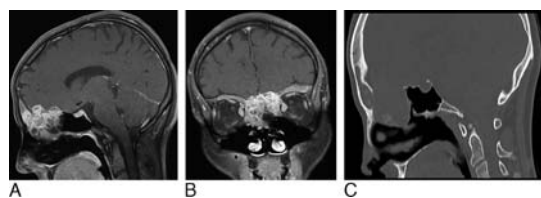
T1-weighted sagittal MRI (A) and T1-weighted coronal MRI (B) show a multiseptated, trabeculated mass lesion, which occupied ethmoid sinuses, expanded through nasal cavity and frontal lobes, with a diffuse heterogeneous contrast enhancement. Sagittal reconstruction paranasal CT (C) shows the anterior skull base destruction and thin bone lamellas into the lesion.
